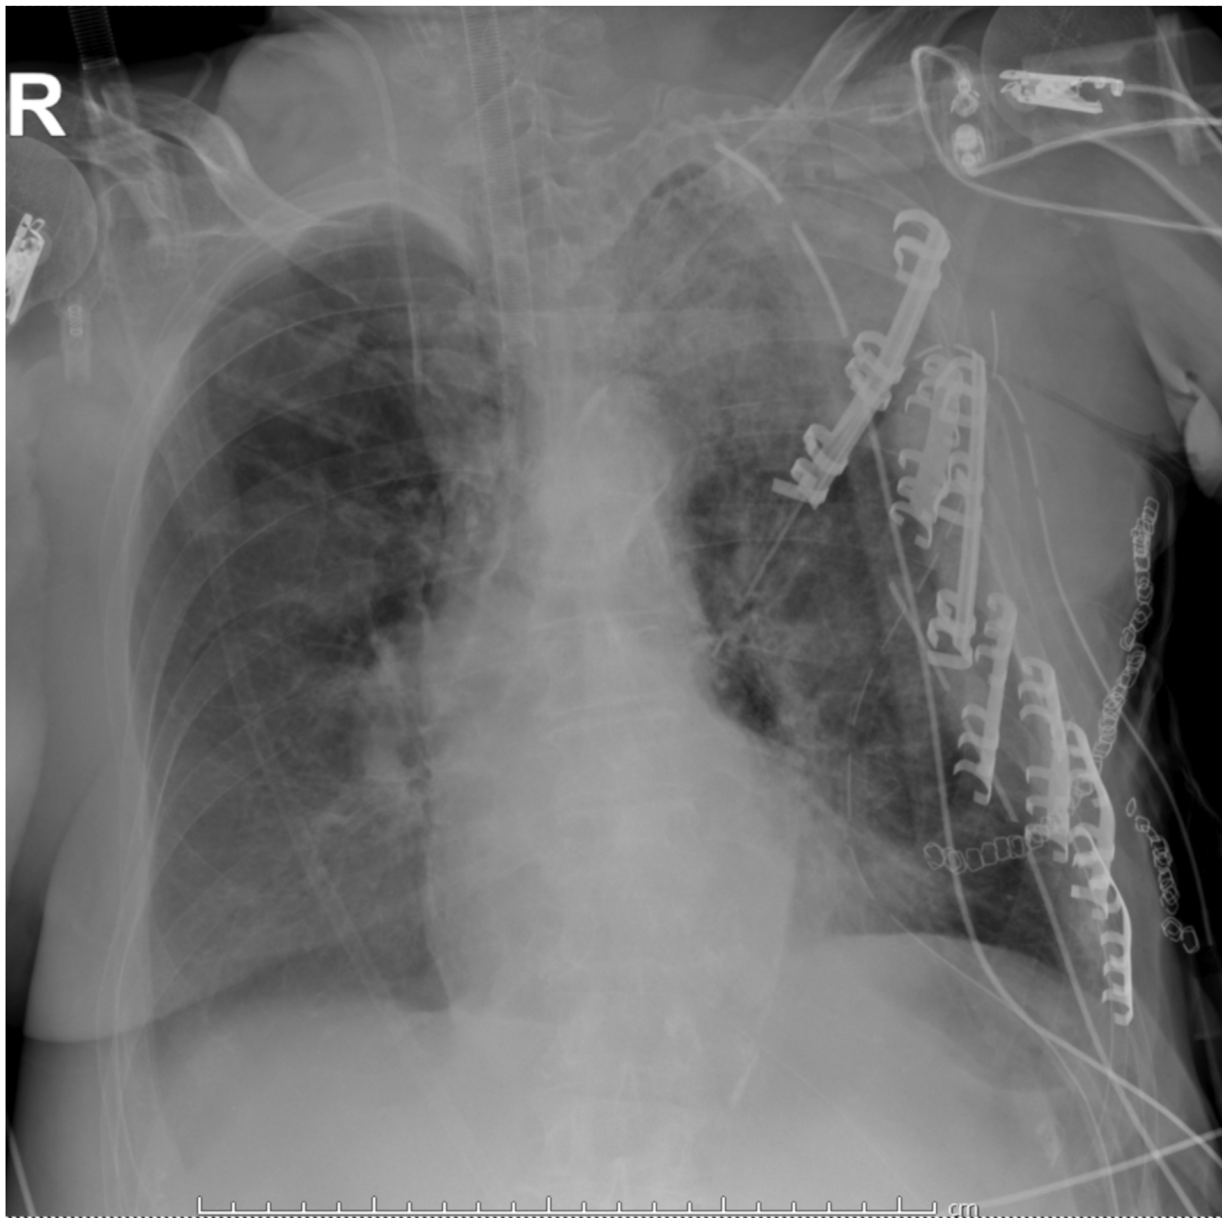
Post-operative chest roentgenogram showing the left chest armor made of metallic plates.
